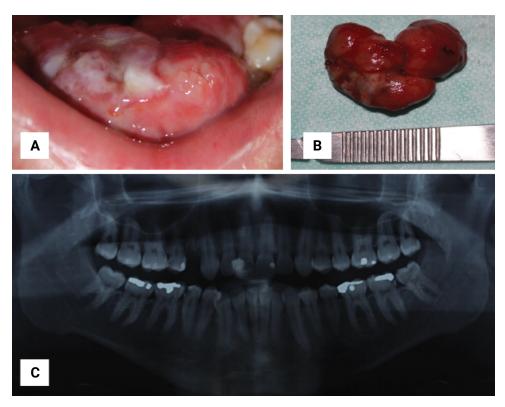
Clinical presentation of non-neural granular cell tumor (A-C). A - Erythematous, polypoid, nodular lesion with foci of superficial ulceration located in the lower alveolar ridge and floor of the mouth. B - Preoperative panoramic radiograph showing no signs of bone or dental involvement. C - Macroscopic view of the lesion showing a polypoid appearance and smooth surface.
